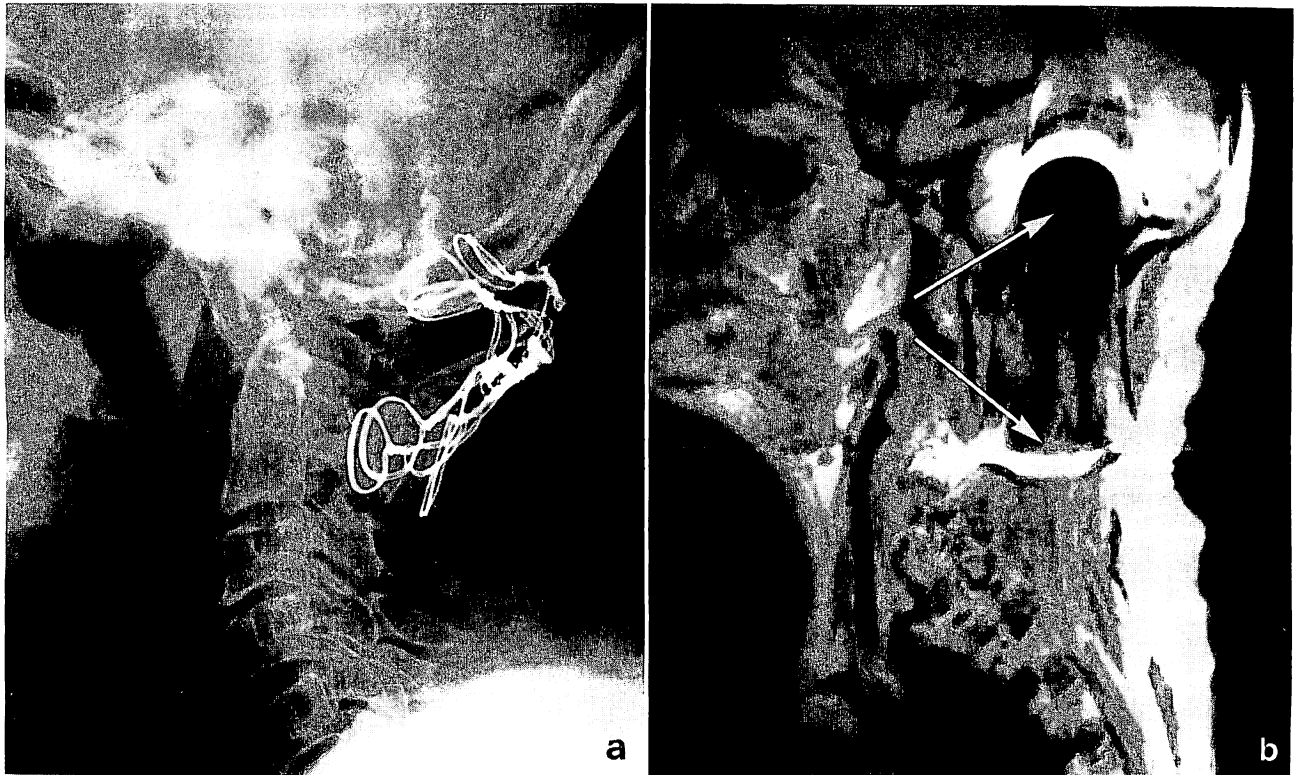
Metallic artifact (large metal object). A 65-year-old male with atlanto-axial dislocation. Lamina of the axis was removed and iliac bone grafted for posterior fusion with surgical wires. a) A lateral cervical film. The grafted bone and surgical wires are noted. b) T1-weighted SE image. Local image is markedly distorted by surgical wires (arrows)
